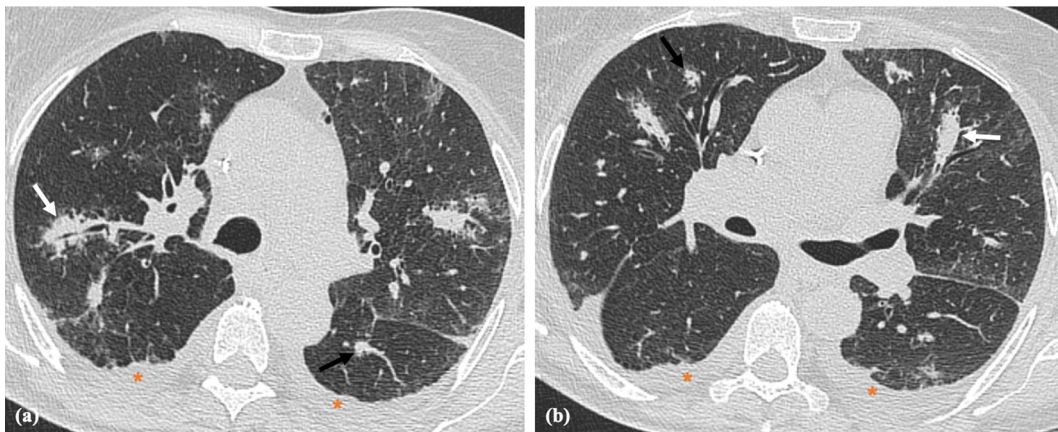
Airway-invasive pulmonary aspergillosis in a 56-year-old female with non-Hodgkin lymphoma undergoing chemotherapy. Sputum examination demonstrated actively multiplying colonies of *A. fumigatus*. Serum was also positive for galactomannan. CT scan from upper (a) and lower (b) levels
